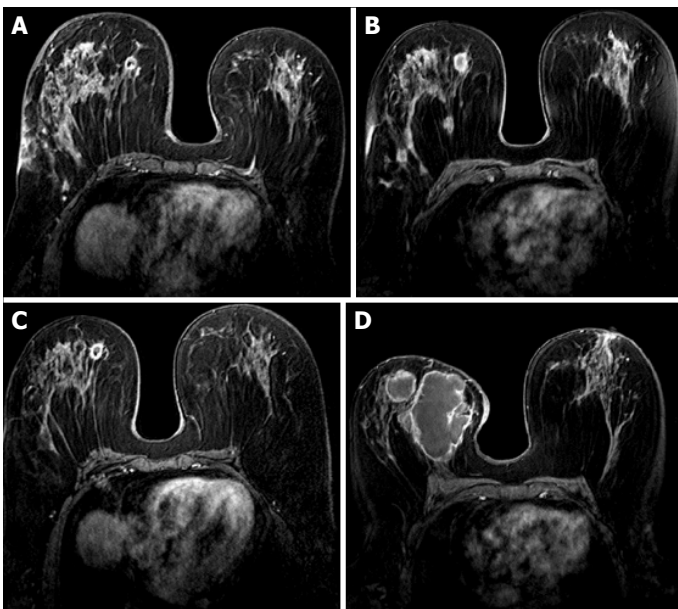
(A) Skin thickening, NME and abscess in the right breast in pre-treatment MRI. (B) Three abscess formations in the MRI 7 months later. (C) One residual abscess in MRI 13 months later. (D) Abscesses compatible with recurrence on MRI 26 months later.
